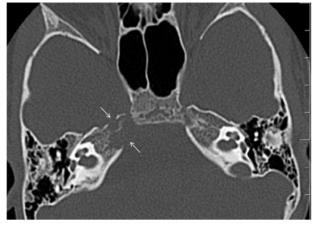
On axial CT image bone expansion and cortical osseous thinning with prominent loss of integrity especially at the proximal of the right petrous apex is seen. Also minimal soft tissue density is visible in some of the mastoid cells on the right.
